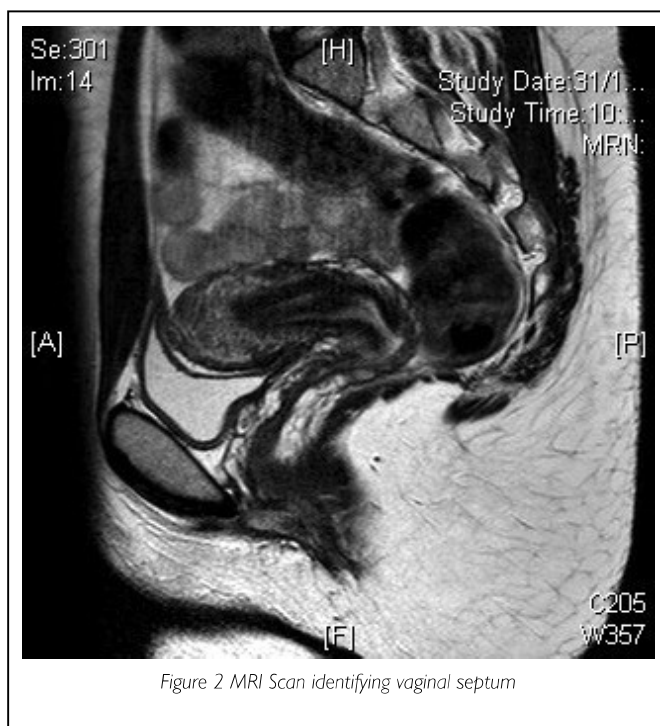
MRI Scan identifying vaginal septum
